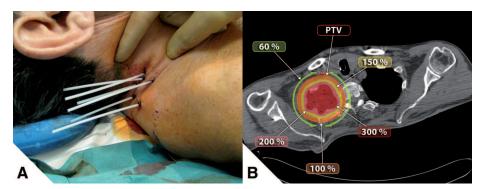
A 74-year-old man with adenocarcinoma of the right-sided superior sulcus. The radiation-naive patient rejected surgery and radiochemotherapy and was treated by sole interstitial high-dose-rate brachytherapy receiving four fractions of 8.0 Gy over 2 consecutive days to a total physical dose of 32.0 Gy. *A*, Image of the interstitial implant after completion of the computed tomography (CT)-guided catheter insertion procedure. The six flexible catheters are fixed at the entrance points on the skin surface by surgical suture. *B*, Axial CT image with superimposed two-dimensional (2D)-isodose distribution after CT-based three-dimensional (3D)-treatment planning for a plane lying centrally to the target extension. The color gradation represents red = 300% isodose = 24.0 Gy, pink = 200% isodose = 16.0 Gy, yellow = 150% isodose = 12.0 Gy, orange = 100% isodose = 8.0 Gy, and light green = 60% isodose = 4.8 Gy. The tumor volume is red delineated (PTV) with the six implanted catheters identifiable as dark dots inside it. The central tumor volume is covered at least by the 300% isodose and receives total doses of at least 96.0 Gy within 48 hours. The spinal cord is only marginally covered by the 60% isodose and receives a fractionated total dose far below 20.0 Gy.
